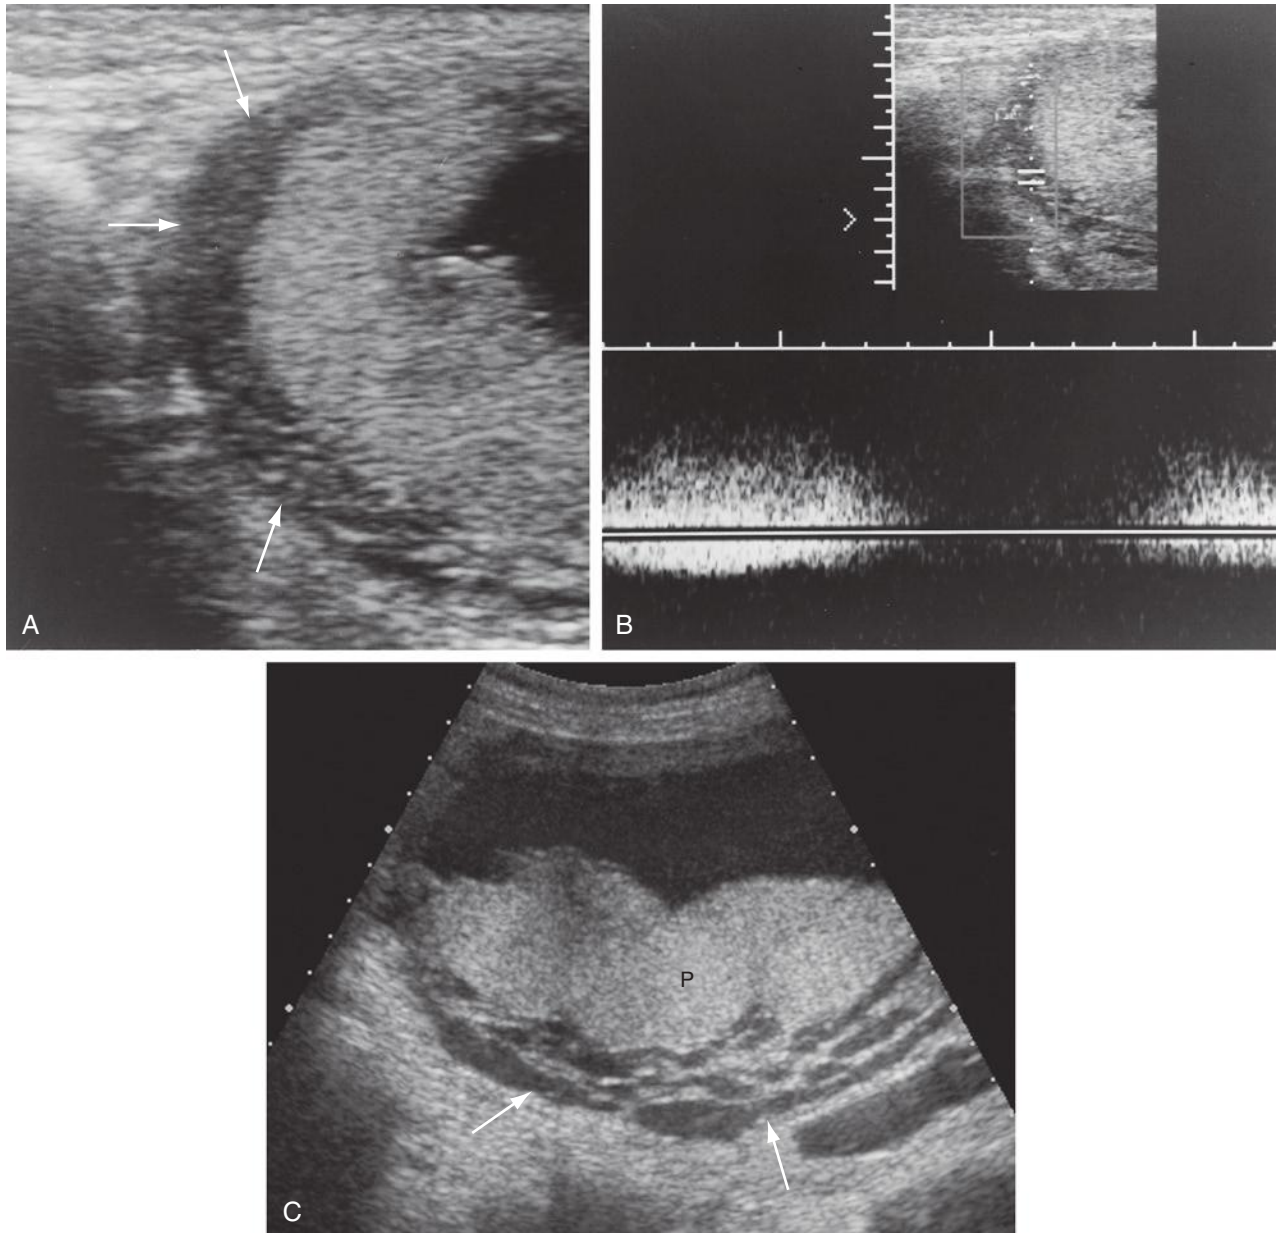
A, Veins present in the decidua basalis and myometrium contribute to a hypoechoic region beneath the placenta (*arrows*). This should not be misinterpreted as an abruption. B, Doppler interrogation of this region will often confirm the venous nature of this area. C, In this case, the veins (*arrows*) deep to the placenta (P) are clearly seen.
